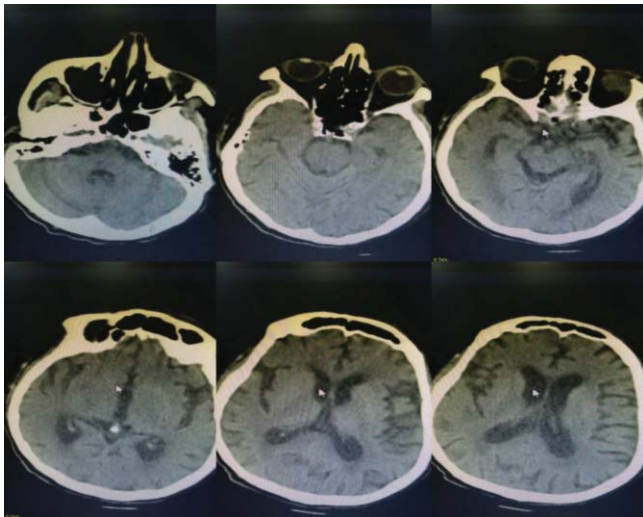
CT scan brain showing no gross findings.
